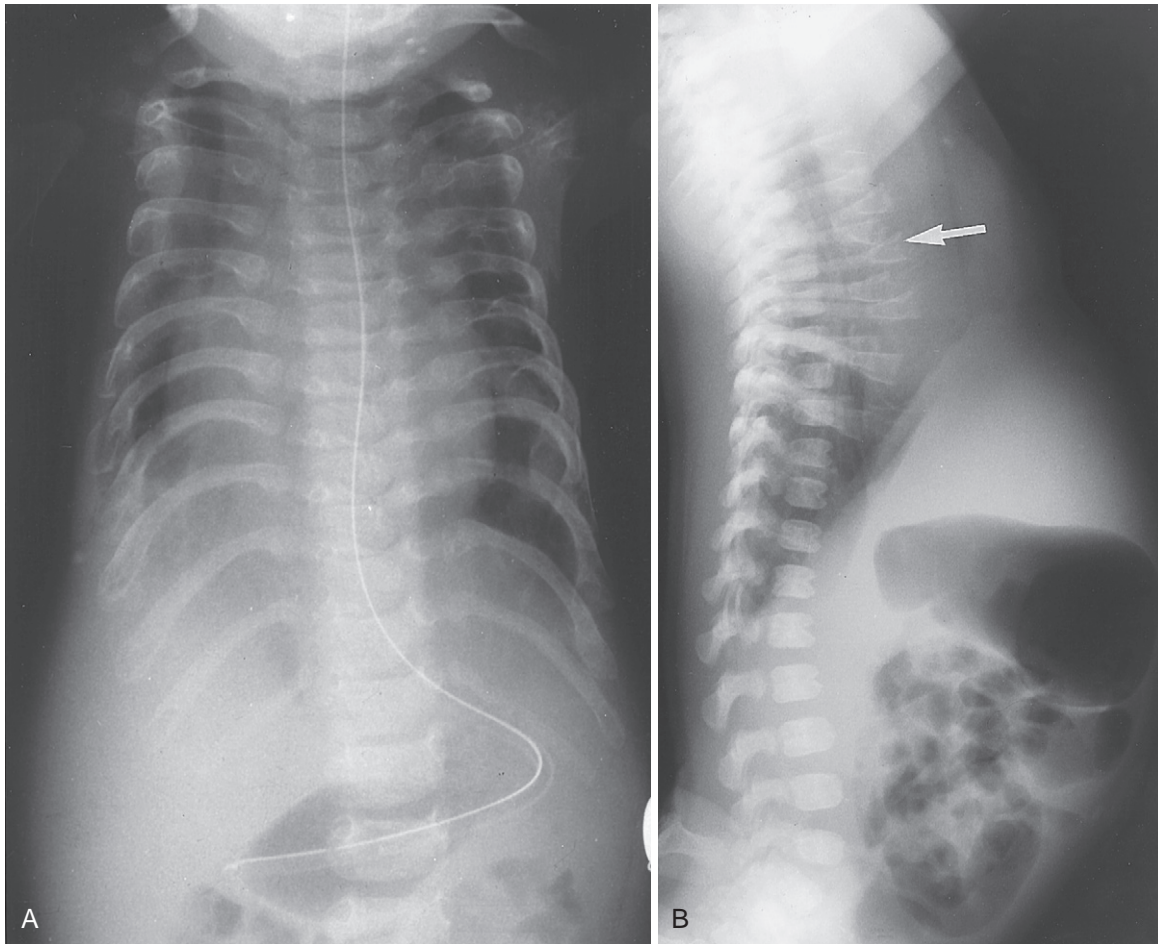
A, Anteroposterior radiograph shows the short horizontal ribs and narrow chest of an infant with Jeune syndrome (asphyxiating thoracic dystrophy). B, Lateral radiograph demonstrates the short rib ends ending at the midaxillary line (arrow) and abnormal flaring at the costochondral junction. The infant died of progressive respiratory insufficiency at 1 month of age, and postmortem examination revealed alveolar hypoplasia. (From Shamberger RC: Chest wall deformities. In Shields TW [ed]: General Thoracic Surgery, ed 5. Philadelphia, Lippincott Williams & Wilkins, 2000.)
